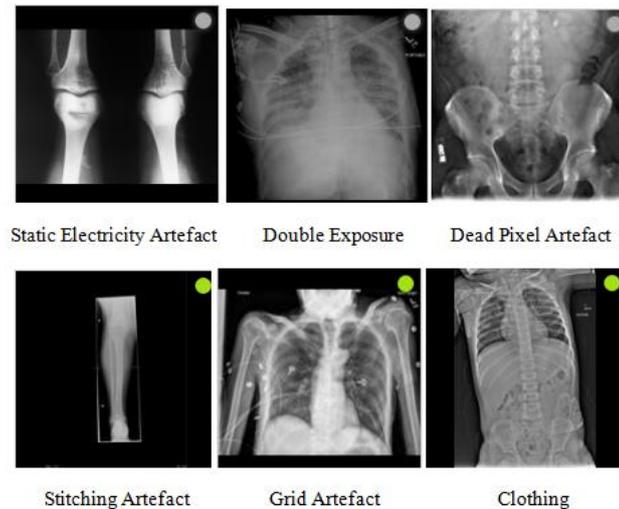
Common X-Ray Artefacts [23]
